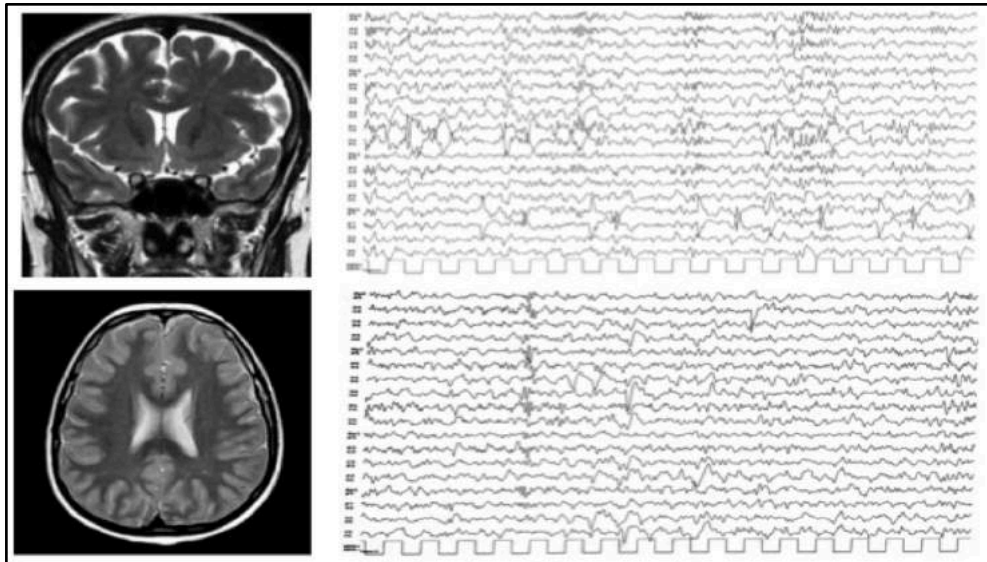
MRI and sleep-deprived patients' EEGs imaging showing no brain structural anomalies and same items of frontal spike wave and multiple spike discharges.
